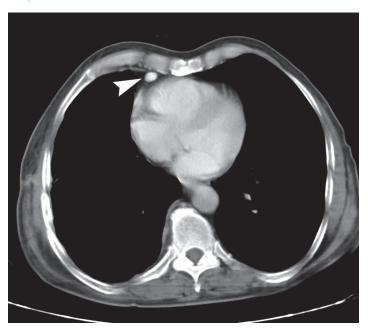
Axial contrast enhanced CT show 1 cm paracardiac lymphadenopathy in 65 year old man with MPM.
